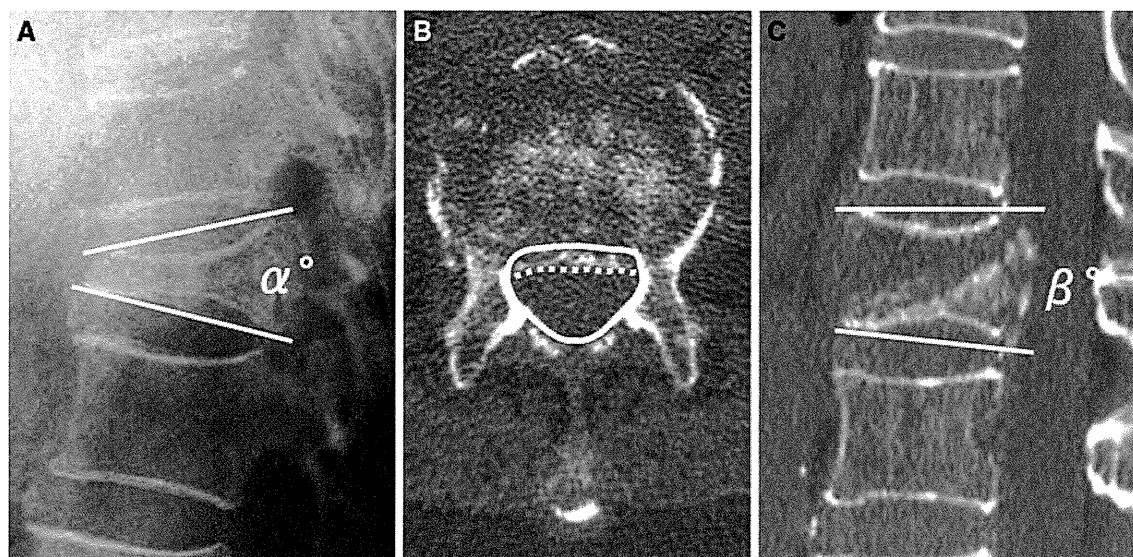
Three radiographic parameters demonstrating a “local kyphotic angle” (α°) measured using Cobb’s method with the patient in a sitting position and b “percent spinal canal compromise” calculated by dividing the area of intrusion by the total spinal canal area multiplied by 100. The total canal area is outlined by the *solid line*; the area of the retropulsed vertebral wall is demarcated by the *dotted*
